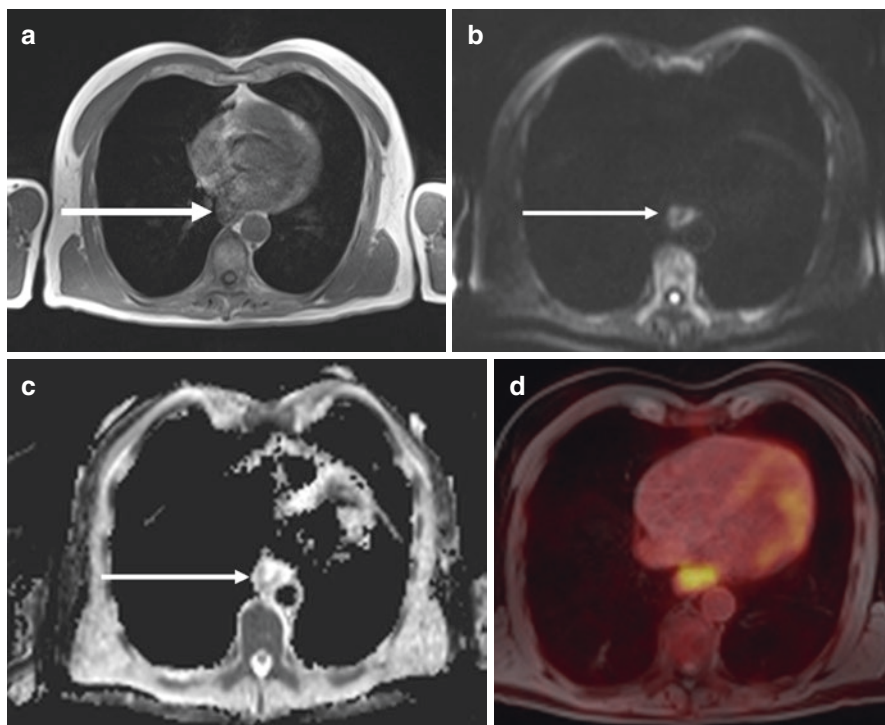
[18F]-FDG-PET/MRI imaging of distal esophageal adenocarcinoma. (a) Axial T1-weighted gradient-echo sequence without fat suppression (T1-VIBE_DIXON sequence). The lesion in the distal esophagus is hardly appreciated. Note respiratory and cardiovascular motion artefacts. (b, c) Diffusion-weighted imaging. Using this technique, areas of restricted Brownian motion of hydrogen protons, which occurs for instance in dense tumor tissue, can be displayed. (b) shows the image with a so-called high b -value, whereas (c), the ADC (apparent diffusion coefficient) map, displays the relative differences in diffusability across tissues. Dark signal in this case means restricted diffusion, or dense tumor tissue. (d) On the fused [18F]-FDG-PET/MRI image, the lesion is clearly demonstrated in this region with a strong uptake of [18F]-FDG. Note, that [18F]-FDG-PET/MRI is currently only used for research purposes at academic institutions, since it is not available yet for broad clinical applications
